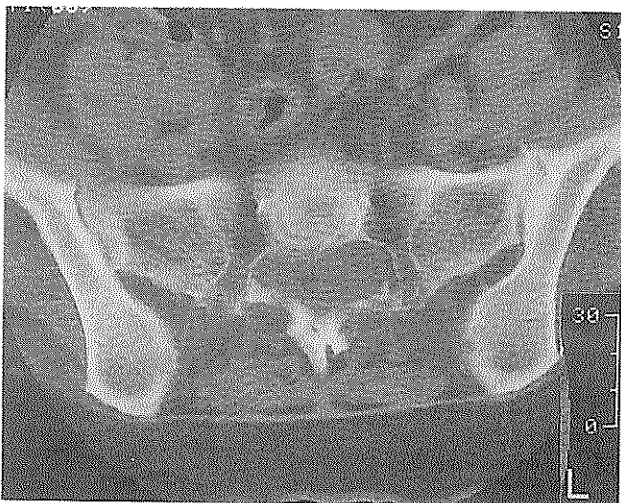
Spinal CT showing hypodense expansile cysts in the sacral canal with marked erosion of posterior element of sacrum.
